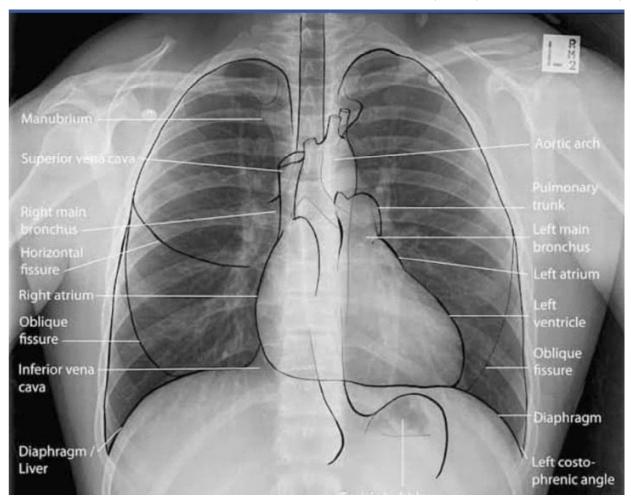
Anatomical landmarks on X-ray chest
